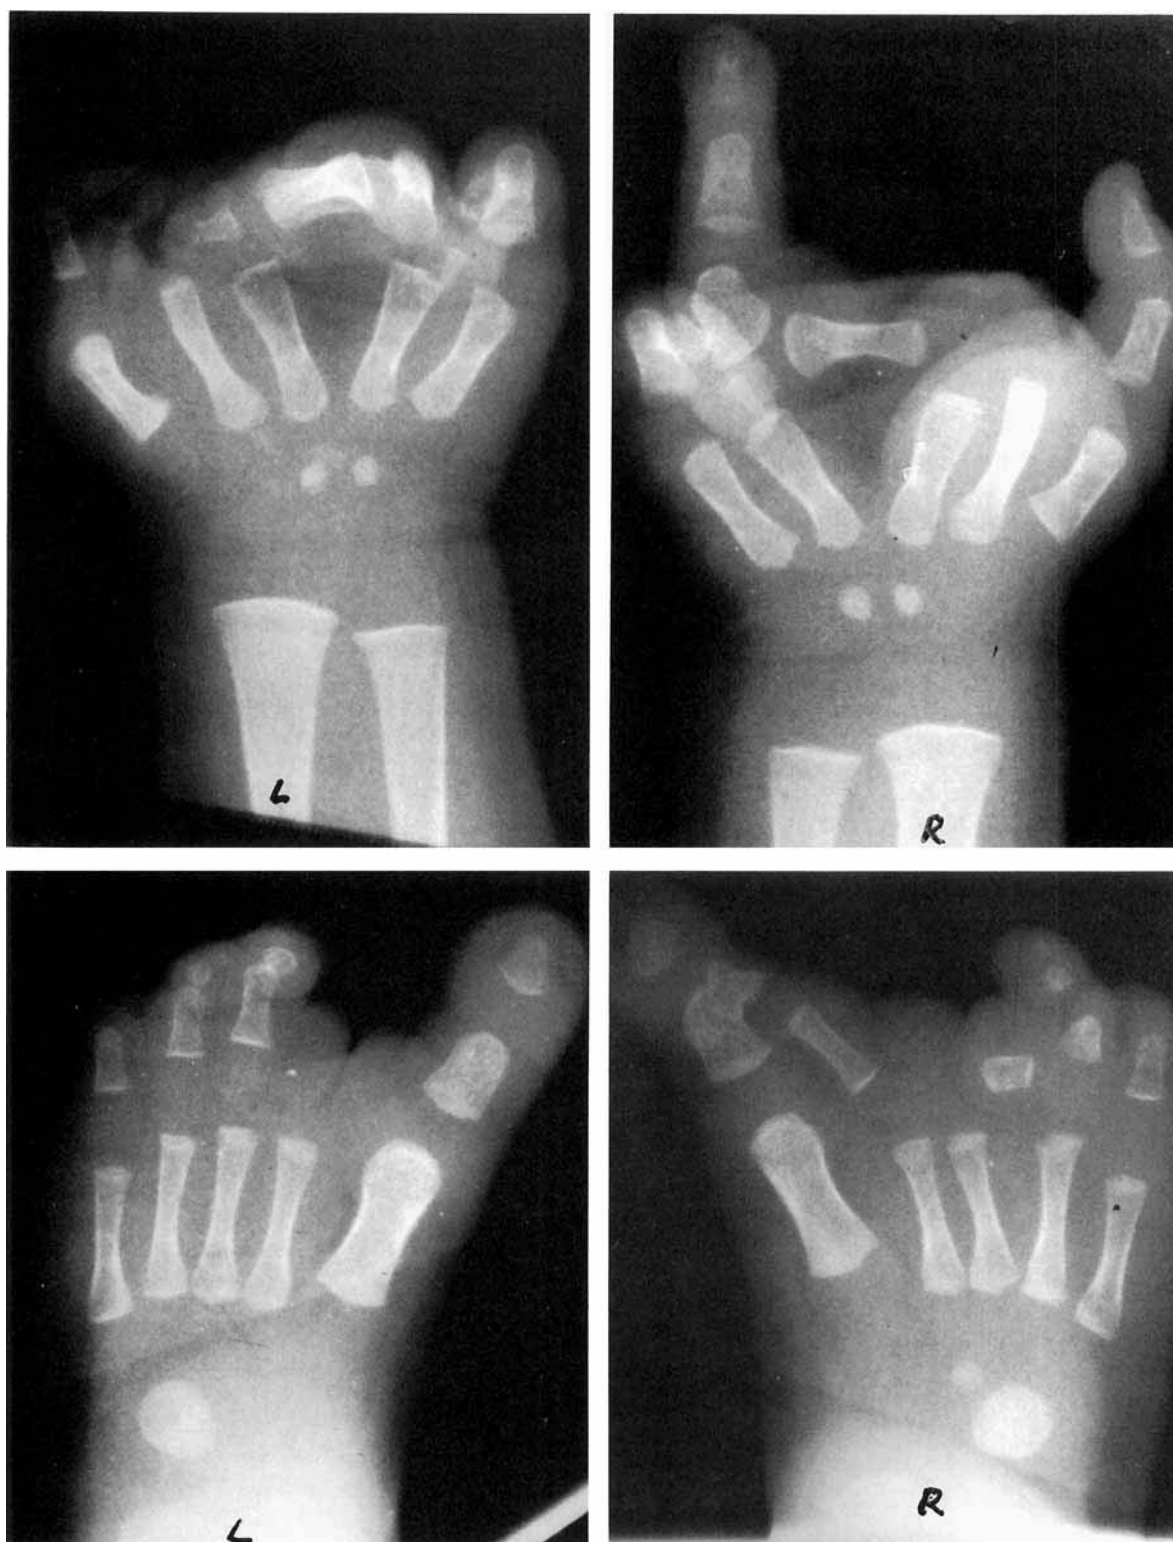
Roentgenogram of the hands and feet demonstrating typical split hands and split feet.
